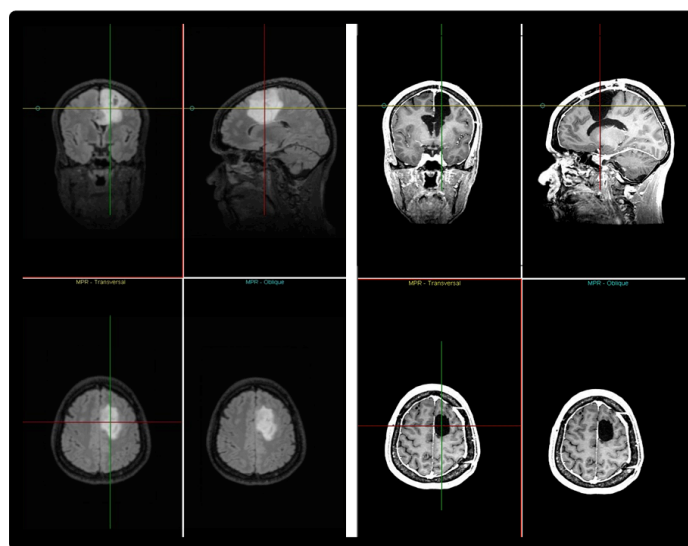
MRI scans of patient #17. Left scan was made pre-surgery (tumor location) and right scan was made post-surgery (location of surgical intervention).
